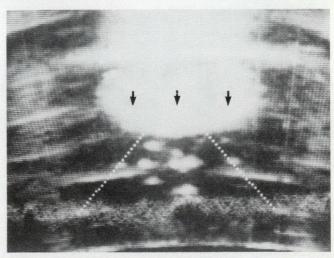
Aspect final de la "vésicule biliaire" et de son contenu (flèches) à la fin de la lithotripsie. Elle est complètement imperméable aux ultrasons sans évidence de cône d'ombre.
